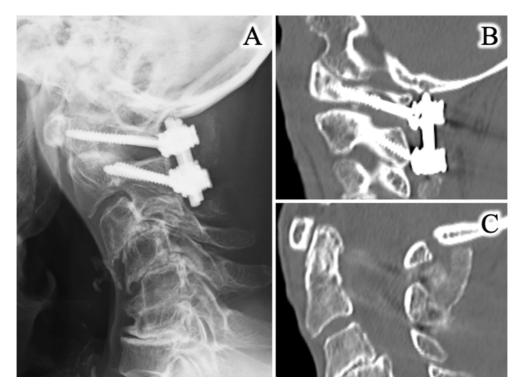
Images after the first operation. (A) (B) X-ray and CT after atlantoaxial fusion using a C1 lateral mass screw and C2 pedicle screw. (C) CT showing bone graft on laminas of C1–C2.
